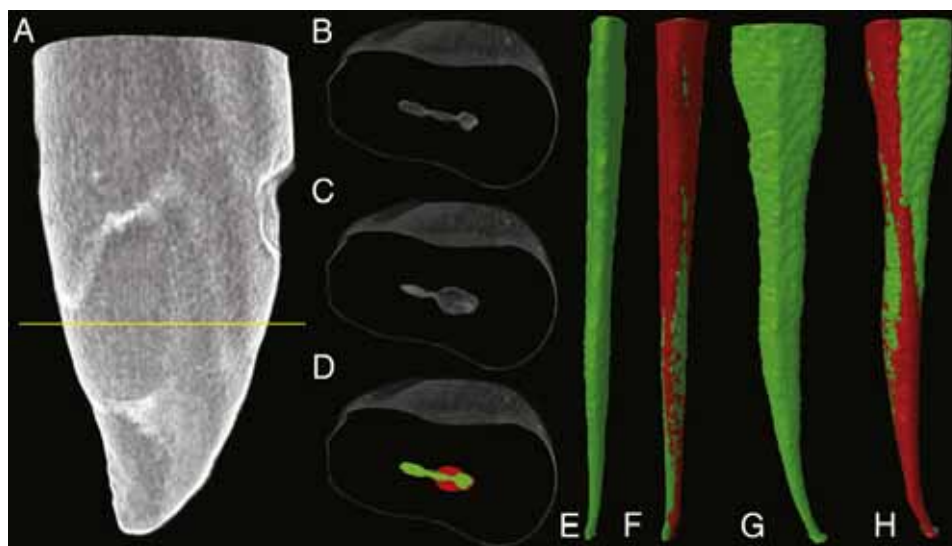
Representative example of μ CT data of flat-oval-shaped root canal of mandibular incisor prepared with K3 rotary system at middle level of the root (yellow line, A). Two-dimensional analysis shows the preoperative (B), postoperative (C), and superimposed reconstructions (D) of the root canal (green and red areas are preoperative and postoperative superimposed cross sections, respectively). Note that rotary instrumentation increased the diameter of the canal, with a round cross section only in its buccal aspect (D). In the qualitative evaluation, three-dimensionally reconstructed μ CT images show the root canal before preparation in buccal (E) and distal views (G). The superimposed μ CT reconstructions in buccal (F) and distal (H) views demonstrate substantial untouched areas after root canal preparation with rotary instruments.
